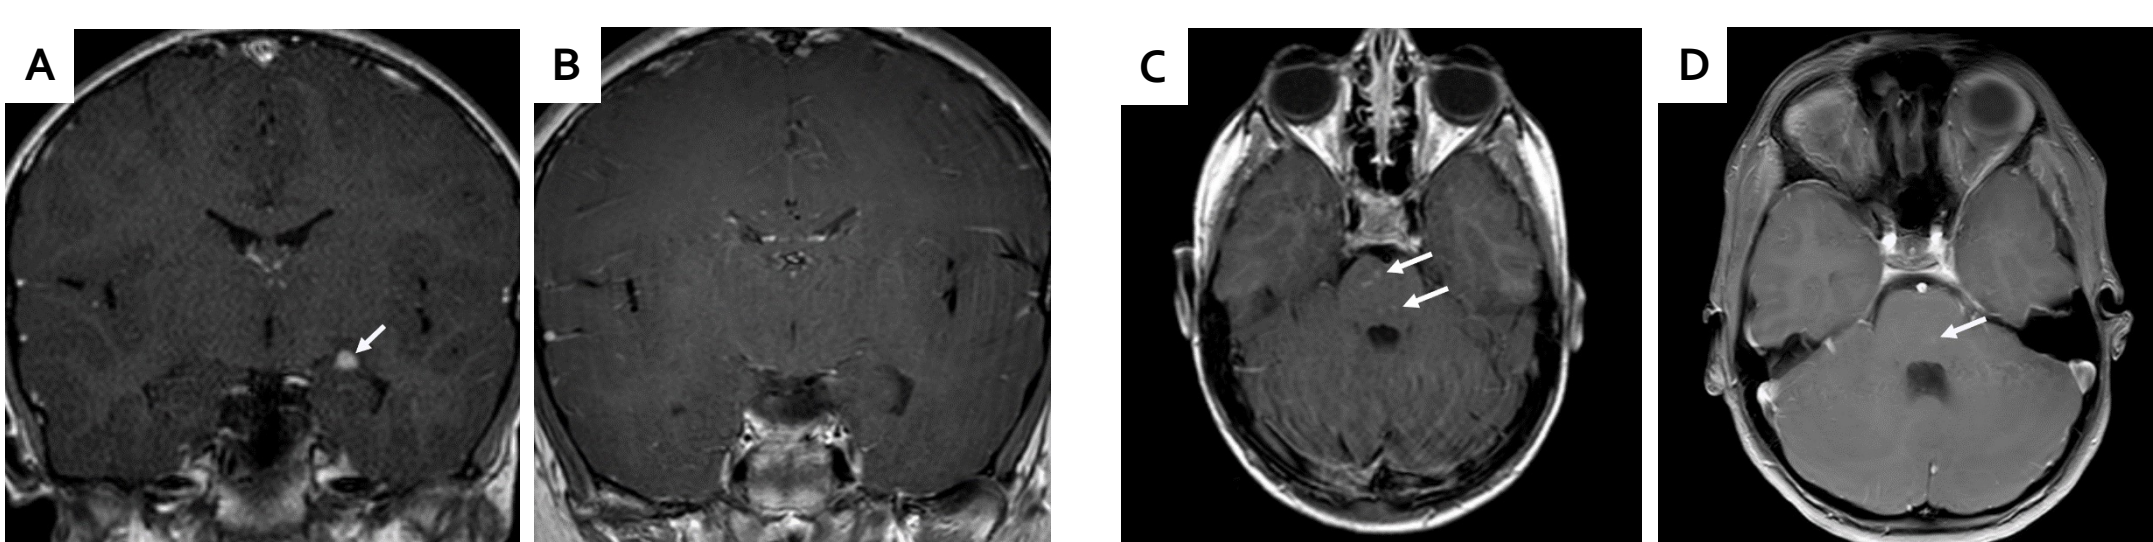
Coronal post-contrast T1-weighted MRI shows an enhancing lesion in the medial left temporal lobe (arrow) (A) and MRI obtained two years later showing interval resolution of the previously identified lesion (B). Axial post-contrast T1-weighted MRI shows multiple small poorly-defined lesions in the pons (arrows) (C) and MRI obtained two years later showing faint residual enhancement in the posterior pons (arrow) with resolution of the other previously identified lesions (D).
